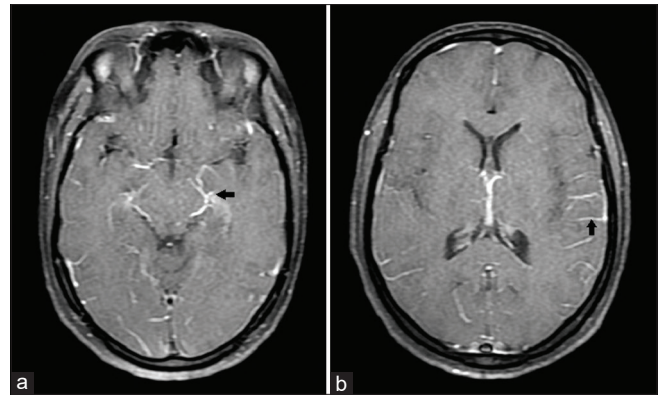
(a) and (b) Patchy leptomenigeal enhancement on an axial section of contrast-enhanced brain MRI, suggestive of meningitis (arrows)
